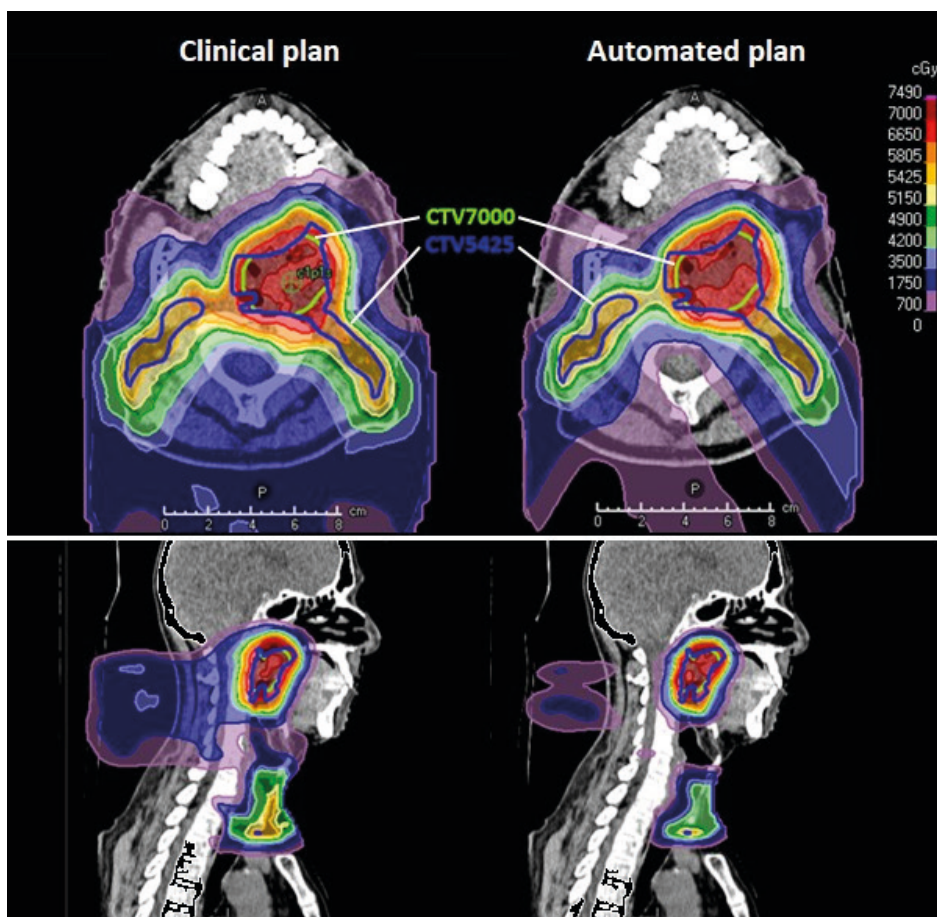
Transversal- (top row) and sagittal cross-sections (bottom row) of a CT with the nominal dose distribution of a clinical plan (left) and an automated plan (right) of one representative patient (patient 30). Note that in the automated plan, the isodose lines conform better to the targets with less dose to the surrounding healthy tissues.
